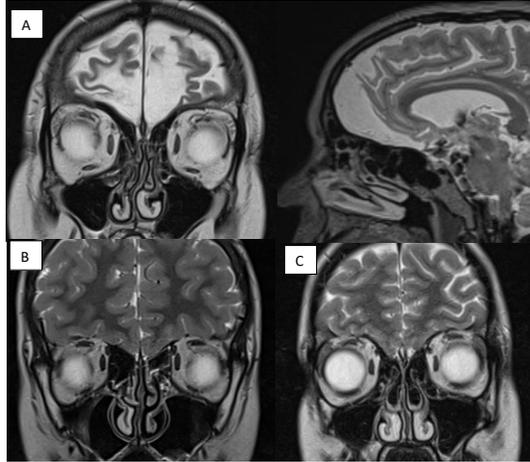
A) Coronal and sagittal T2 weighted MR imaging demonstrating extensive gliosis in an anosmic patient who had sustaining a significant head injury the previous year. B) Coronal T2 weighted MR imaging demonstrating hypoplastic olfactory bulbs in a child with congenital anosmia. C) Coronal T2 MR images demonstrating OCS secondary to an anatomical narrowing with a medialised middle turbinate and concha bullosa. OCS can be clearly demonstrated on both CT or MR imaging and within our cohort was highlighted in some patients during their initial workup for idiopathic anosmia.
